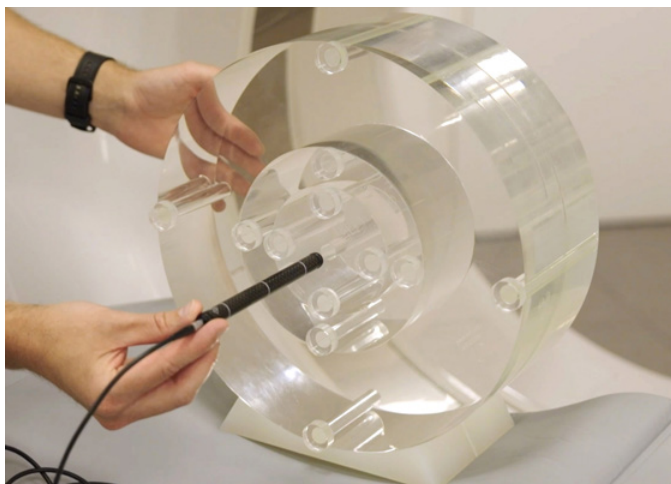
RTI CT Ion Chamber.
